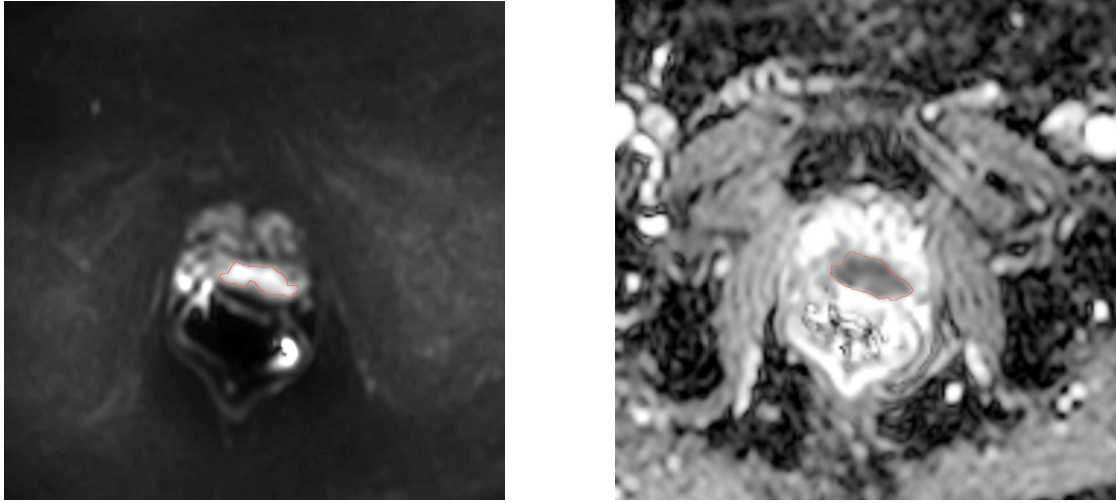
Example of a DWI image and its corresponding ADC map, showing a lesion in the peripheral zone highlighted with a red border
